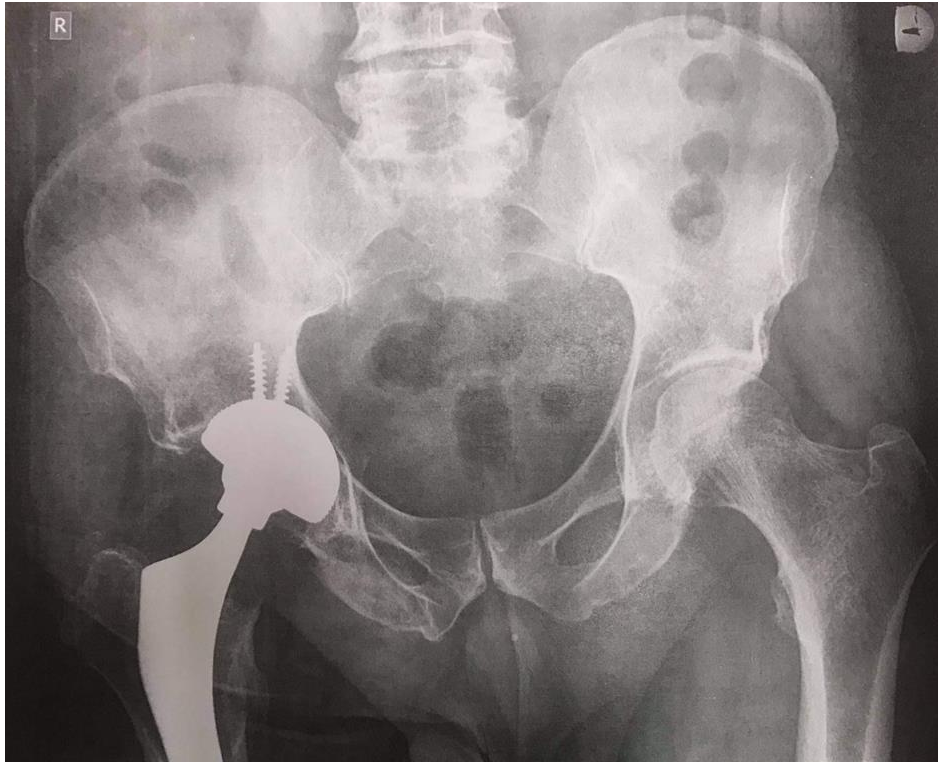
Postoperative radiograph six months after the operation
